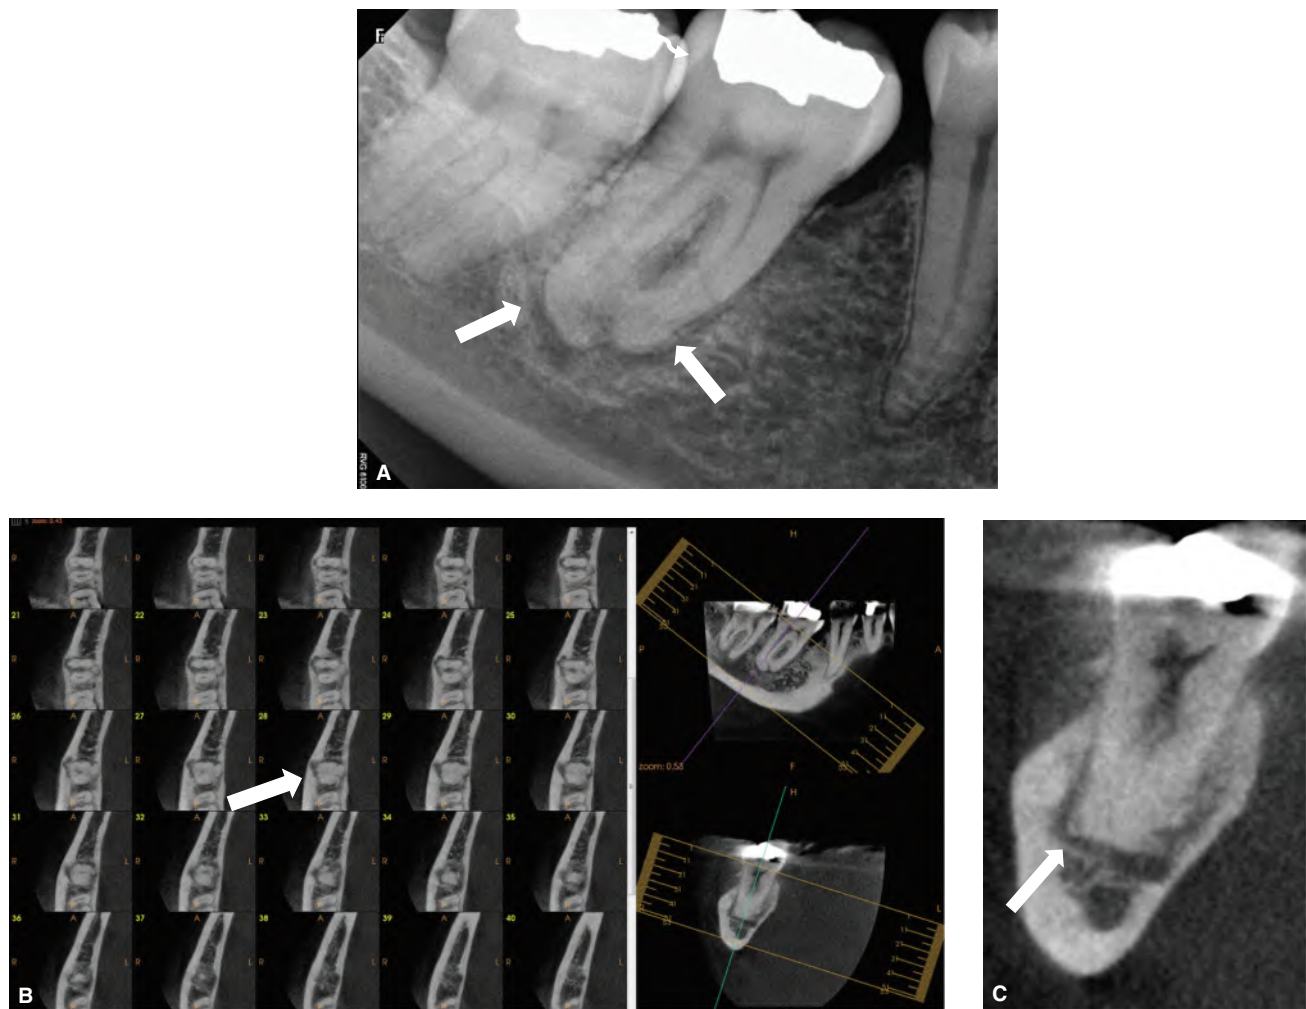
7 A. Periapical radiograph of this 56-year-old African-American female shows the mandibular right second molar with small circular radiolucent bands surrounded by opaque bands approximately 2 mm wide, centered on a point around the apices of the mesial and distal roots (solid arrows). The assessment of this lesion was confounded by a pulpal diagnosis of irreversible pulpitis. B. Correlated and corrected axial reformation showing erosion of the buccal cortex (solid arrow). C. Cross-sectional reformation of the same region showing multiple periapical areas of different densities and hypercementosis of the distal aspect of the distal root (solid arrow). These features were consistent with an irreversible pulpitis with cemento-osseous dysplasia.
